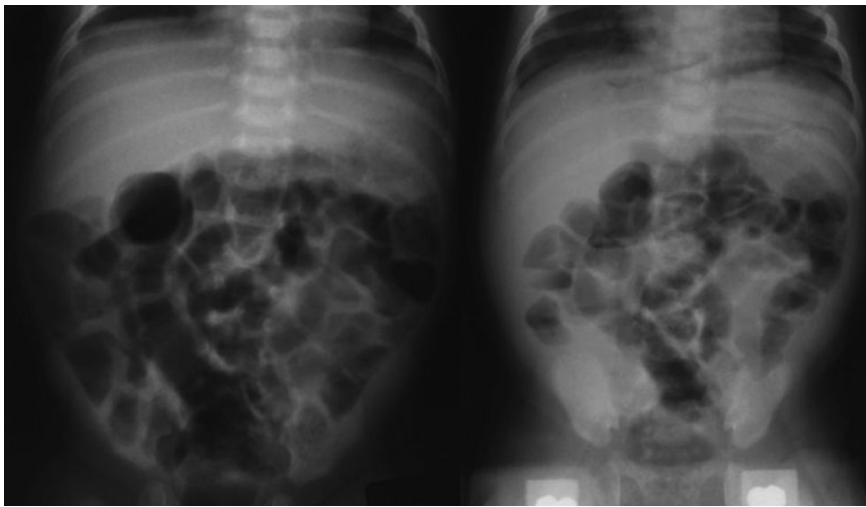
Intestinal pseudo-obstruction confirmed by X-ray.
